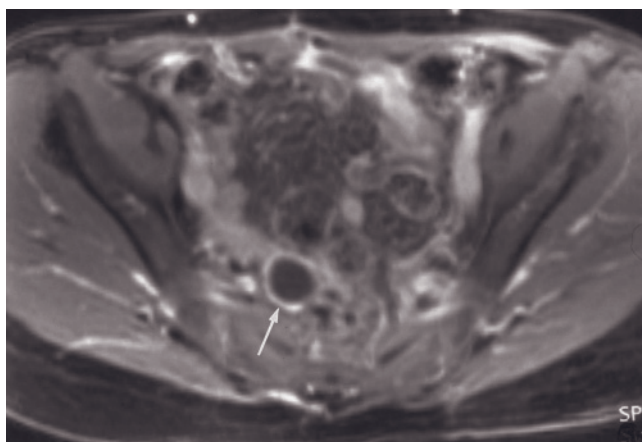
(*Continued*) peritoneal mesothelioma. T1-weighted fat-saturated interstitial-phase postgadolinium 3D-GE (*m*) and T1-weighted interstitial-phase postgadolinium water-excitation magnetization-prepared rapid gradient-echo (*n*) images at 3.0 T show prominent peritoneal thickening (arrows) and intense peritoneal enhancement (arrows) and ascites (*a*) in another patient. The findings are consistent with diffuse malignant peritoneal mesothelioma.
